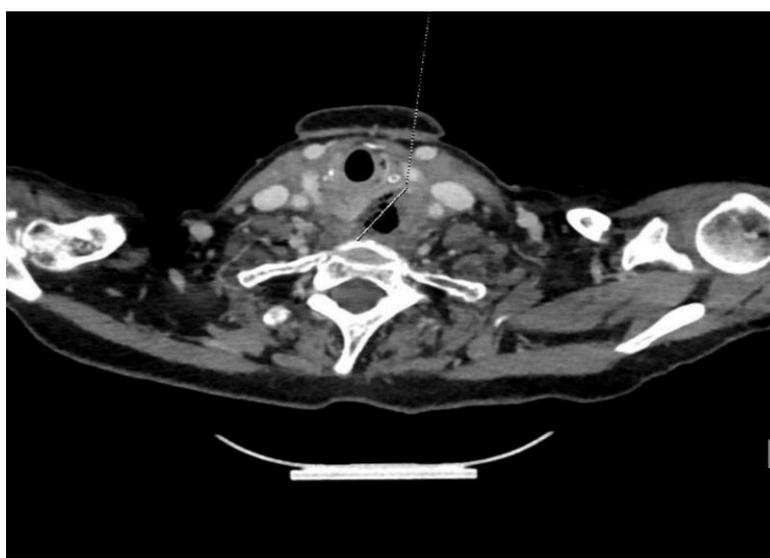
Pre-treatment cervical computed tomography showing the collection with infiltration of soft parts
